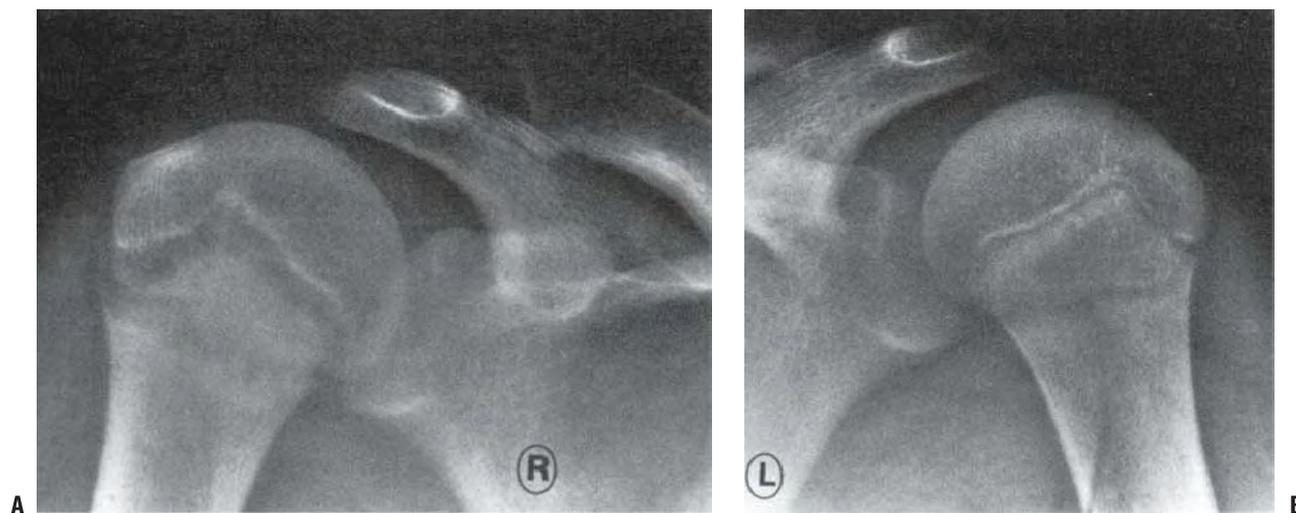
Radiographs of the proximal humerus in a 14-year-old, right-handed baseball pitcher with shoulder pain that progressed over the final few weeks of the season. A: Widening and irregularity of the physeal plate are present in the right shoulder. B: Radiograph of the left shoulder is provided for comparison.
